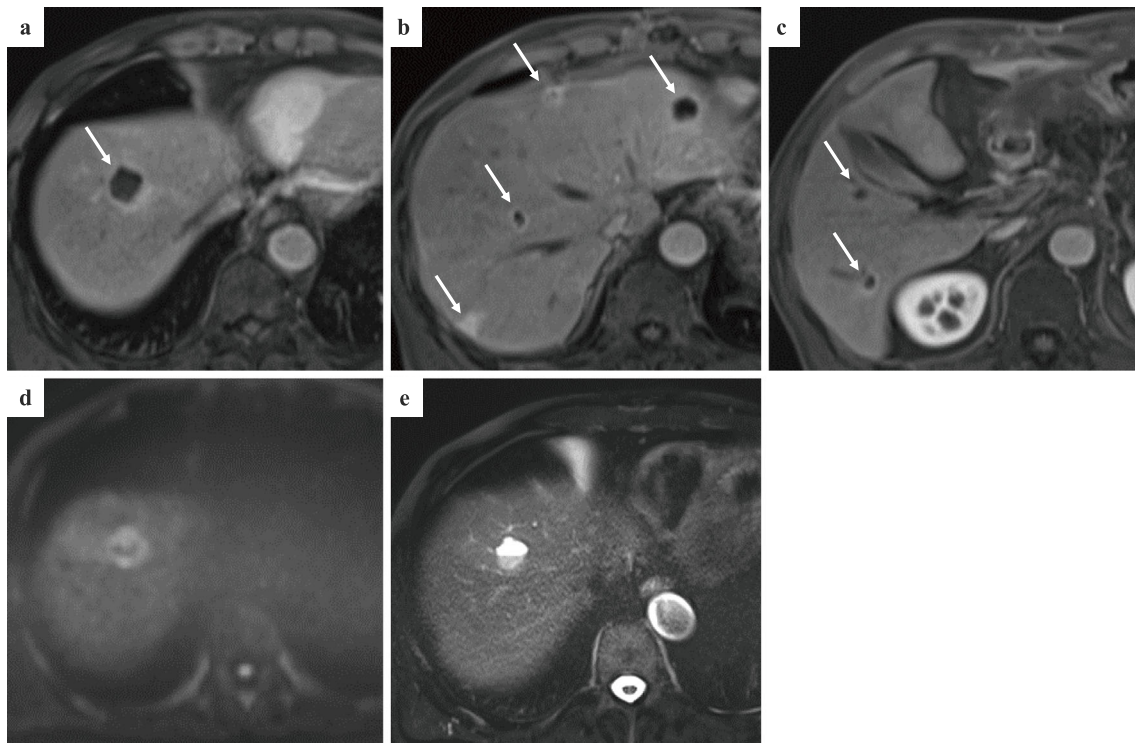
(a-c) One month after the surgery, gadolinium ethoxybenzyl-diethylenetriamine penta-acetic acid-enhanced magnetic resonance imaging revealed new multiple tumors with perilesional ring enhancement in the arterial phase (arrows). (d) Diffusion-weighted image shows perilesional high signal that is not shown in the center. (e) T2-weighted HASTE image shows hyperintense lesions with a fluid-fluid level, which is considered to be an intratumoral hemorrhage. There were no symptoms or blood biochemical findings suggestive of infection; therefore, we ruled out abscesses from our differential, and considered the presence of multiple lesions to be metastases. HASTE: half-Fourier acquisition single-shot turbo spin echo
